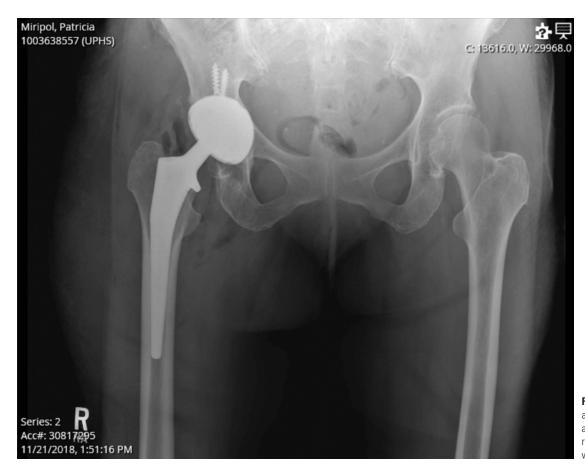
AP pelvis radiograph obtained at time of total hip arthroplasty, approximately 19 weeks following the right hip injection, showing a well-fixed, well-aligned right total hip prosthesis
